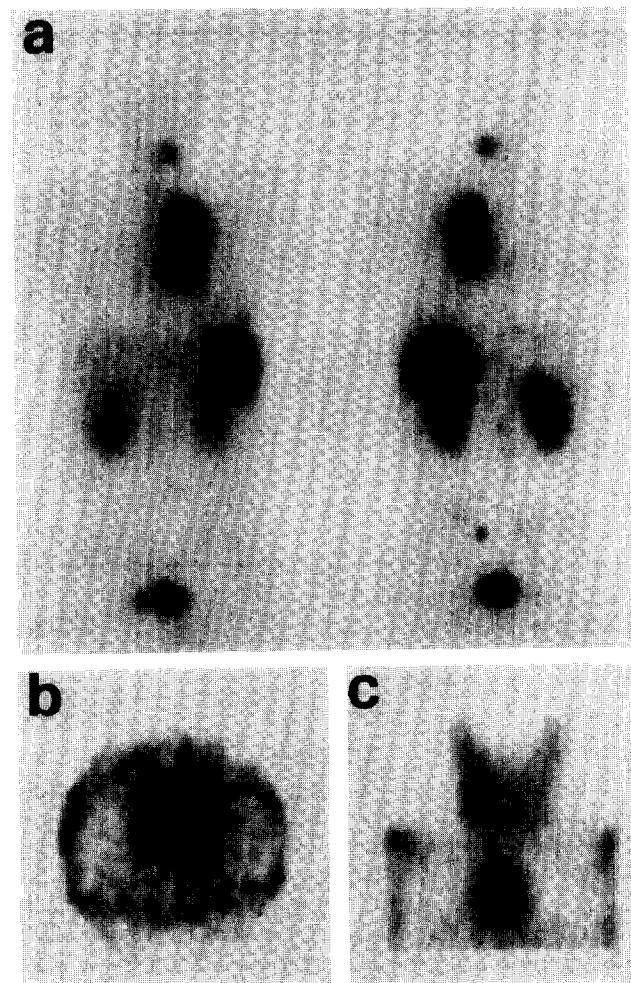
(a). Whole body scintigraphy. Note ¹¹¹In-OCT uptakes in the lung tumour, lymph node metastases (mediastinum and abdomen) and bone metastases (cervical vertebra, lower left rib and pelvis). Normal ¹¹¹In-OCT uptakes are present in the liver, spleen, kidneys and bladder. (b) Axial reconstruction from SPET acquisition of the thorax. Note ¹¹¹In-OCT uptakes in patient with bilateral mediastinal lymph node metastases. (c) Coronal reconstruction from SPET acquisition of the thorax. Note ¹¹¹In-OCT uptakes in patient with lung tumour and lymph node metastases in the mediastinum and the right neck.
